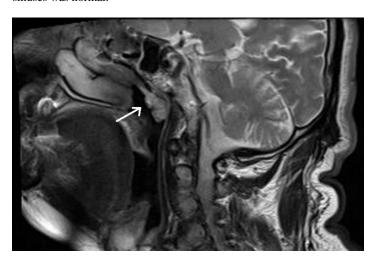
Magnetic resonance image shows the soft tissue density (arrow) started at the level posterior end of middle turbinate and extended to the choana.
